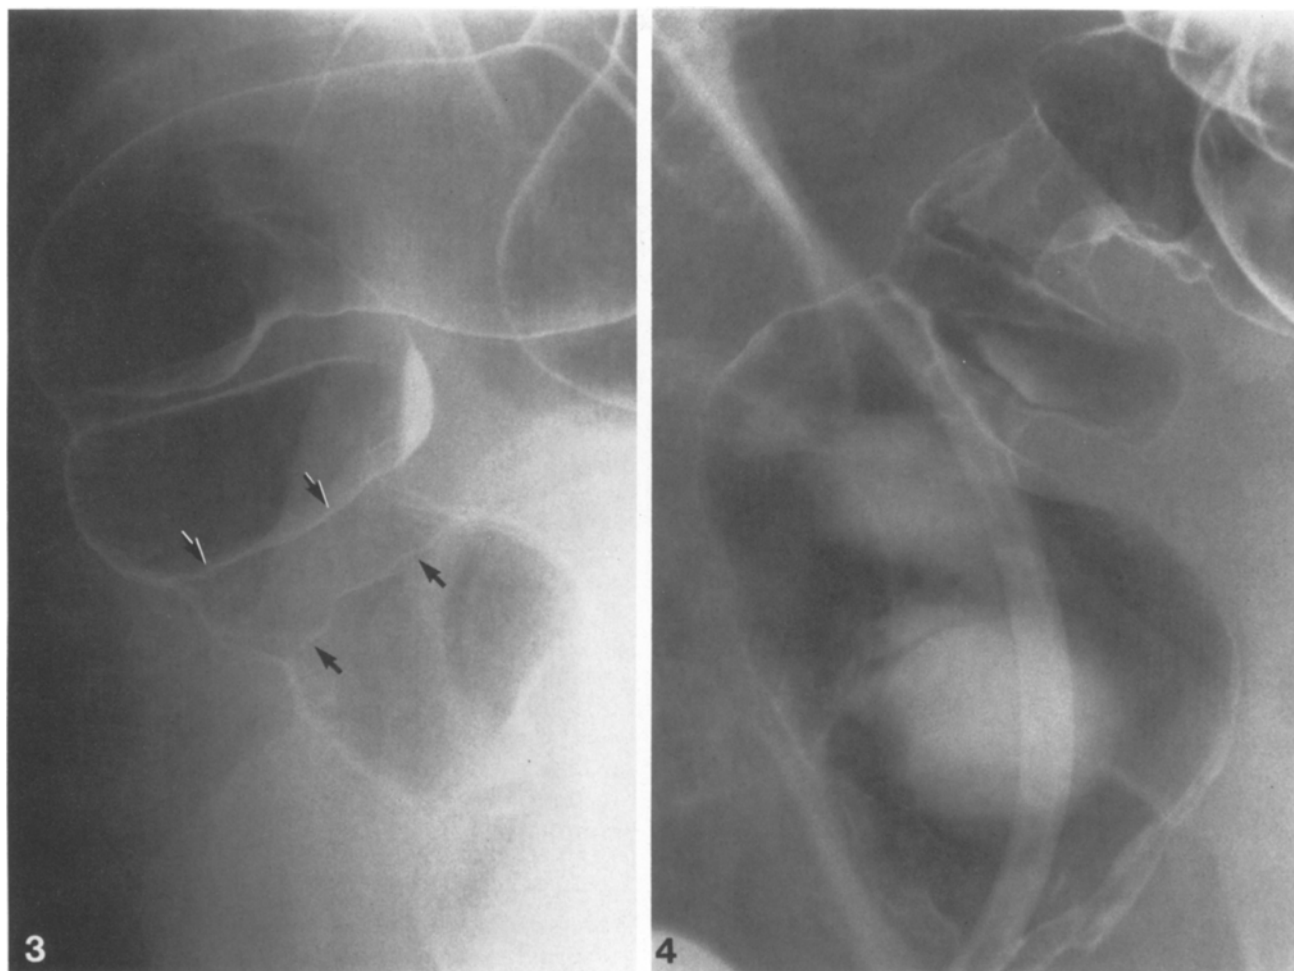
A 33-year-old man with rectal bleeding. Lateral radiograph of rectum shows a markedly thickened, edematous first valve of Houston (*arrows*) without ulceration. This appearance seems to be characteristic of SRUS on the double-contrast examination. At proctoscopy, however, a shallow ulcer was also detected anteriorly 8 cm from the anal verge.
